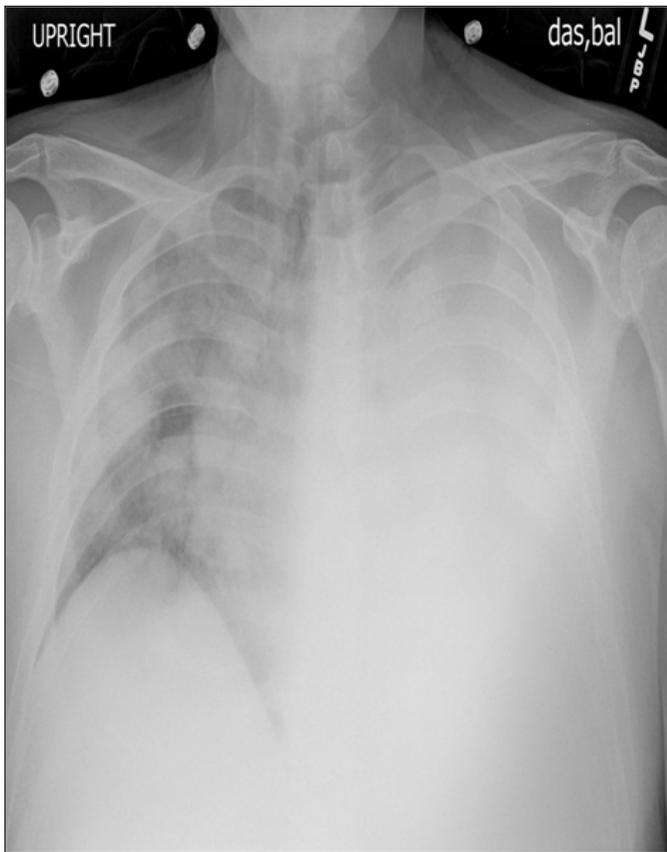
Chest radiograph on admission with opacification of the left lung due to a large pleural effusion prior to pigtail catheter insertion.
